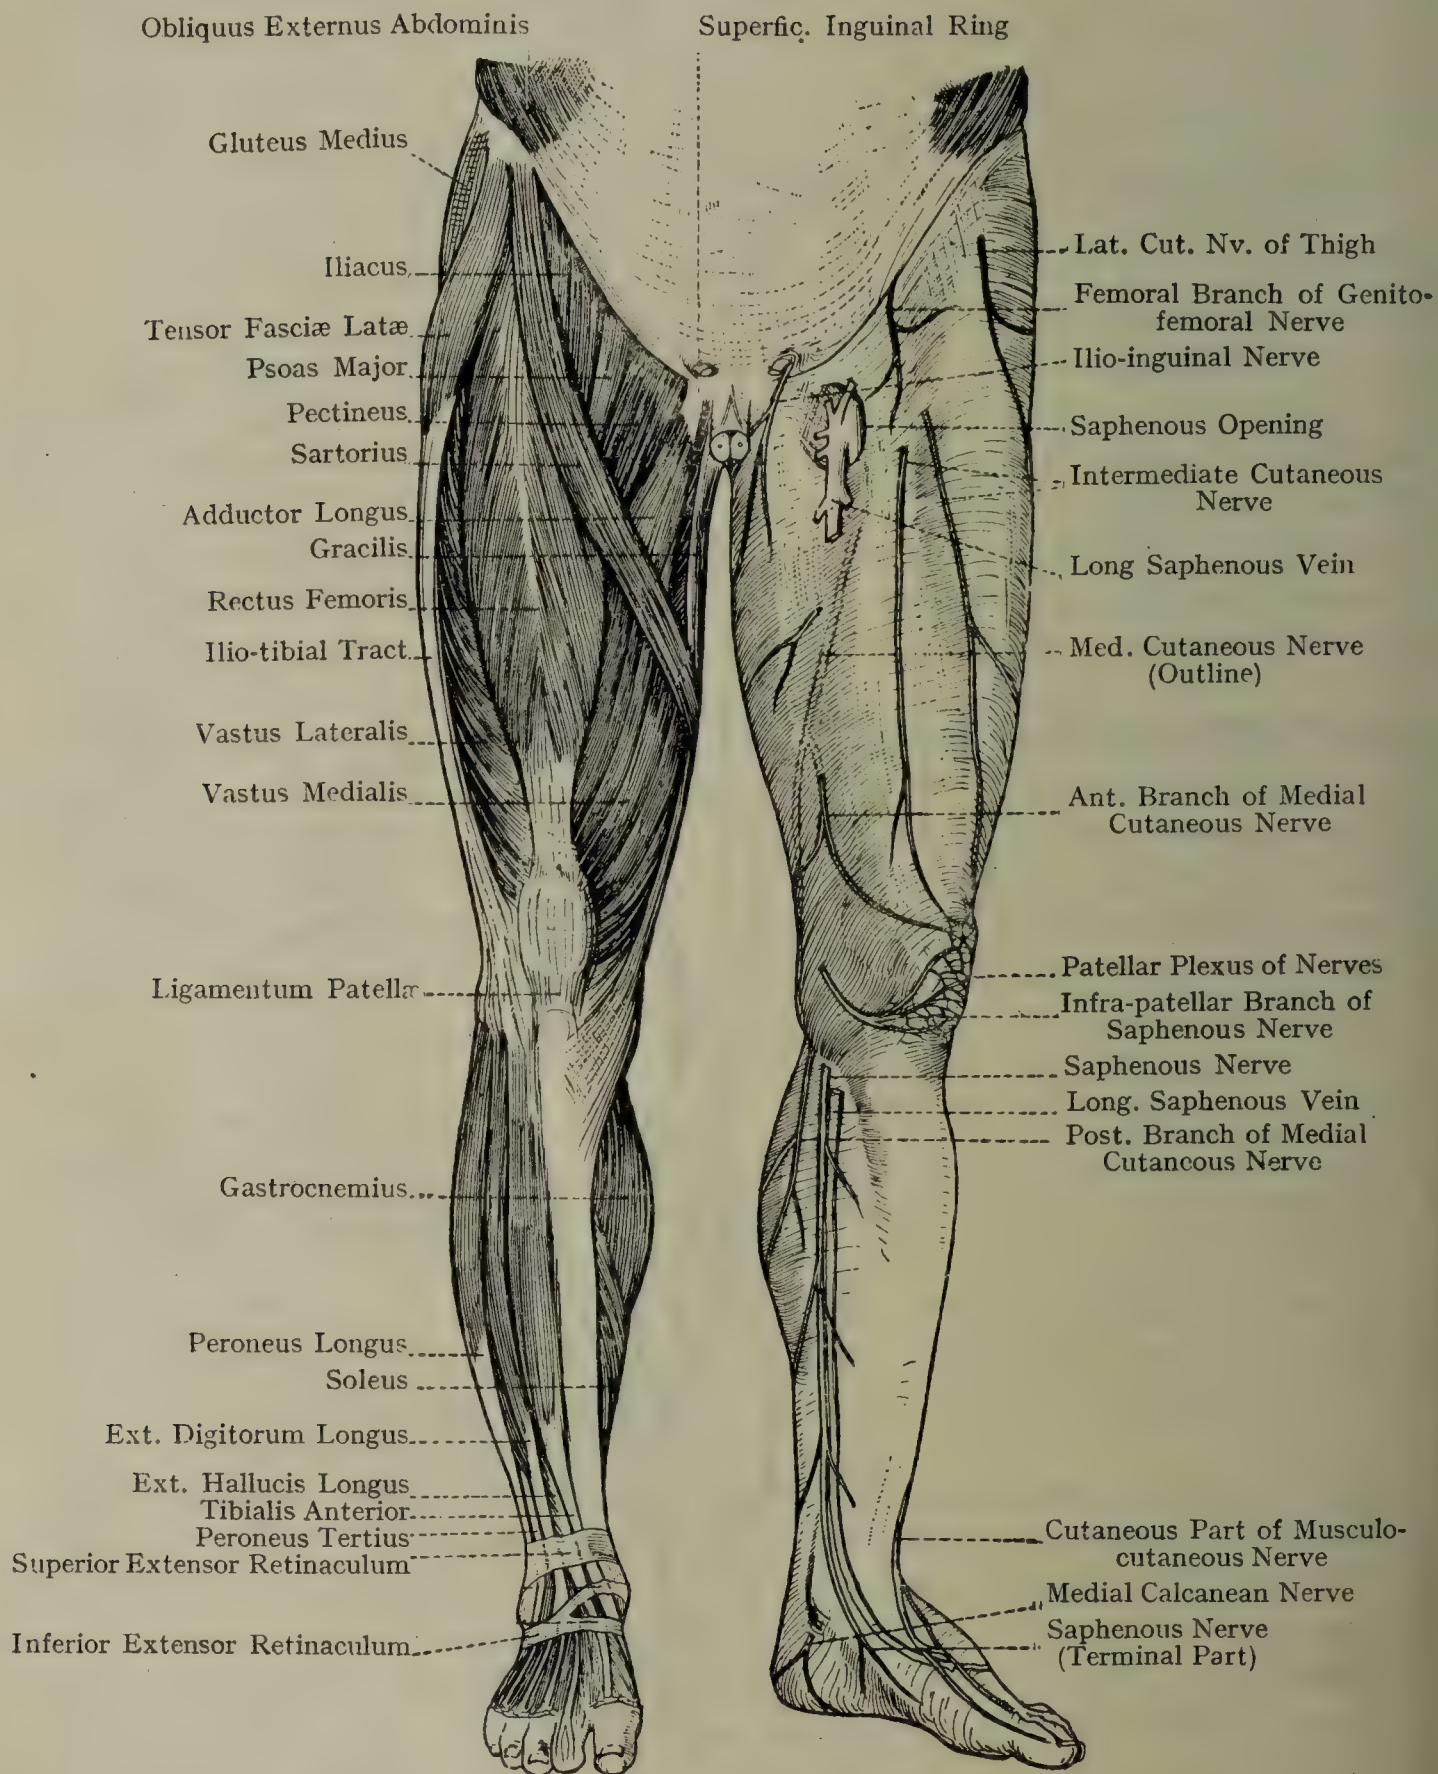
MUSCLES AND CUTANEOUS NERVES OF THE LOWER LIMB (ANTERIOR ASPECT).
